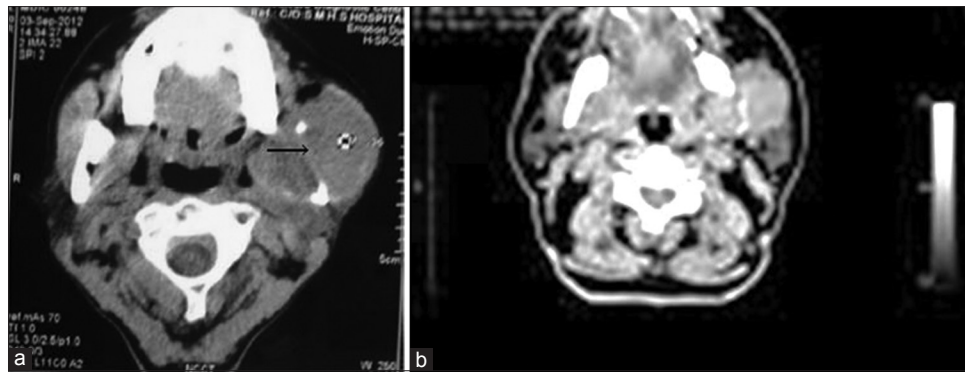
(a) Computed tomography of the parotid region depicting osteolytic lesion in ramus and body of mandible on left side. (b) Computed tomography images showing osteolytic lesion involving the left angle of mandible
